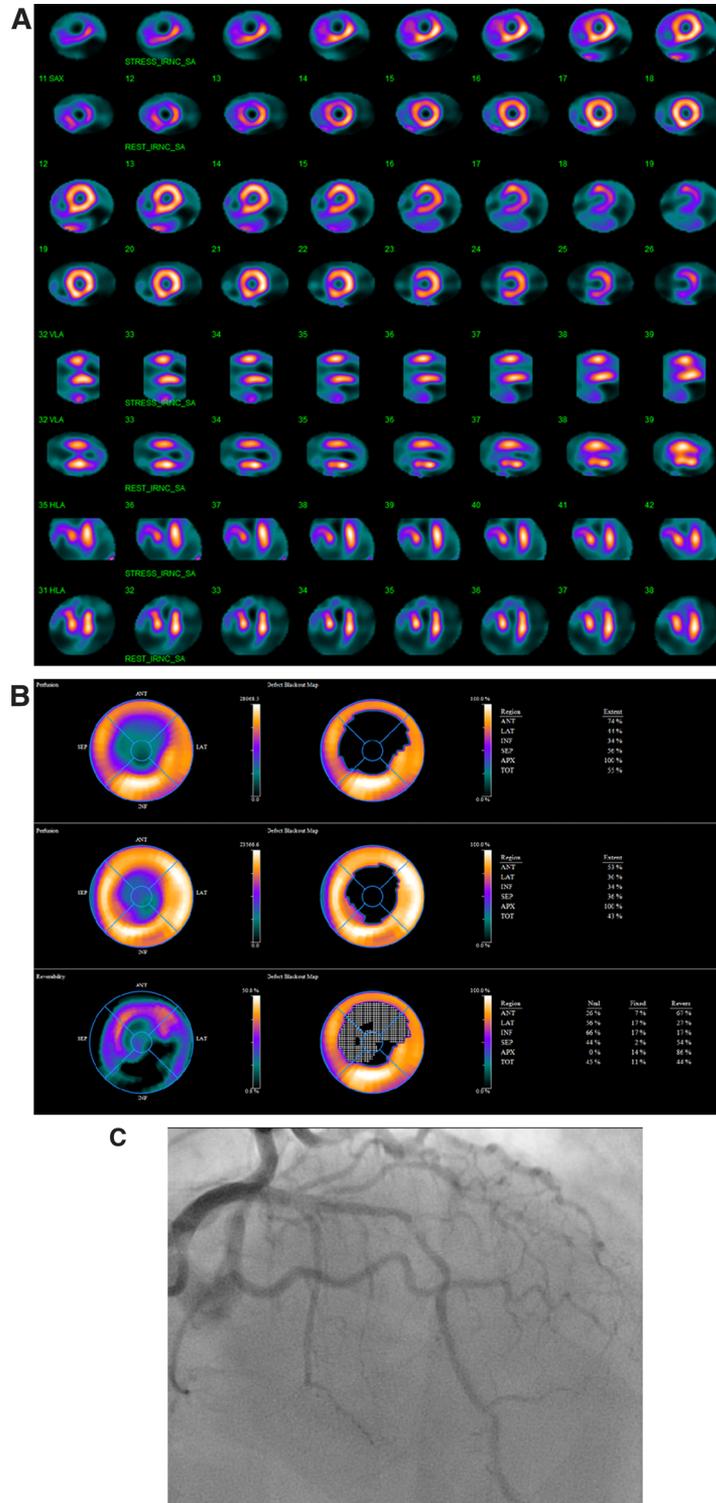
A SPECT MPI study showing a large area of ischemia in the distal septum, mid to distal anterior wall, and apex of the LV involving 50% of the LV myocardium. B SPECT MPI study polar map showing a large area of ischemia in the distal septum, mid to distal anterior wall, and apex of the LV involving 50% of the LV myocardium. C Coronary angiography showing a 95% severely calcified lesion in the LAD.
